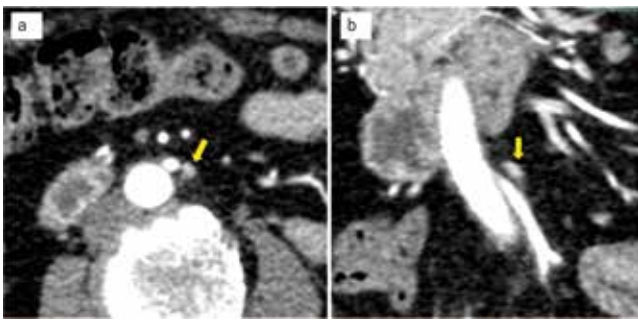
Enhanced computed tomography findings. An axial image (a), a colonic image (b). Enhanced nodule-like regional lymph node near the root of the inferior mesenteric artery (arrow).
